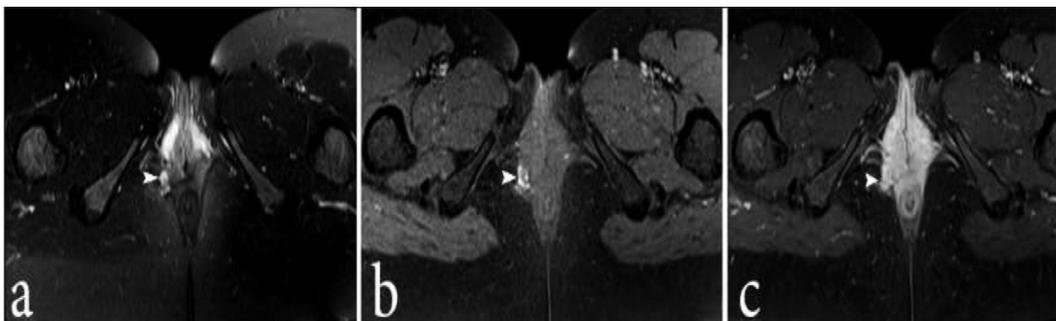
Axial T2-weighted (a) and axial fat-saturated T1-weighted (b) MR images reveal a small nodule at the episiotomy site in the right paravaginal area, which was hyperintense in both sequences because of hemorrhagic content (arrowheads). The lesion shows enhancement on post-contrast axial fat-saturated T1-weighted MRI (c) due to the presence of scar tissue (arrowhead).
